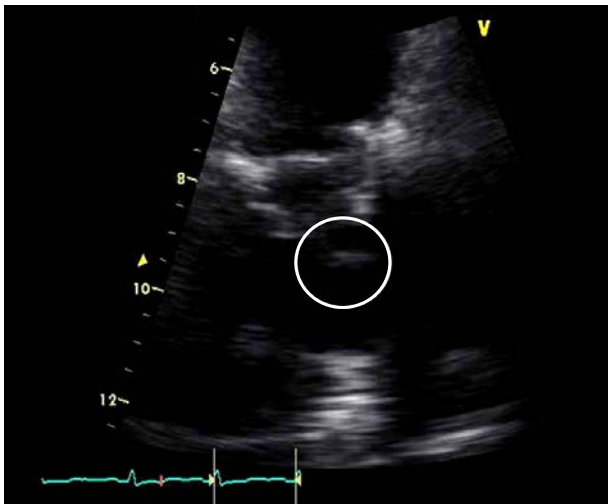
The echocardiography showed a hypoechoic movable mass on the prosthetic pulmonary valve (circle).
